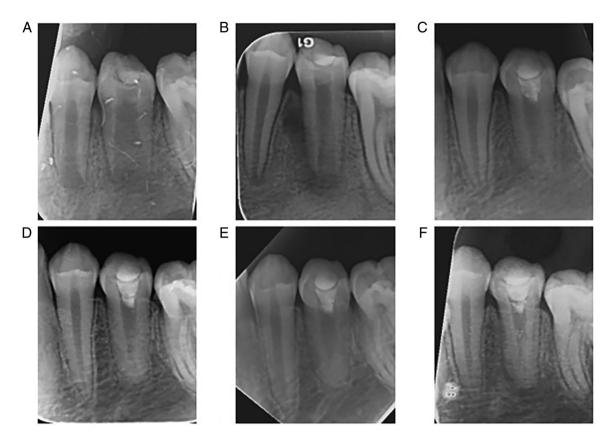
Follow-up periapical radiographs of tooth #35. (A) Preoperative radiograph. (B) 1-year follow-up radiograph after REP; tooth #35 was treated with the second REP. (C) 1-year, (D) 2-year, (E) 3-year and (F) 4-year follow-up radiograph after the second REP. REPs, regenerative endodontic procedure.
